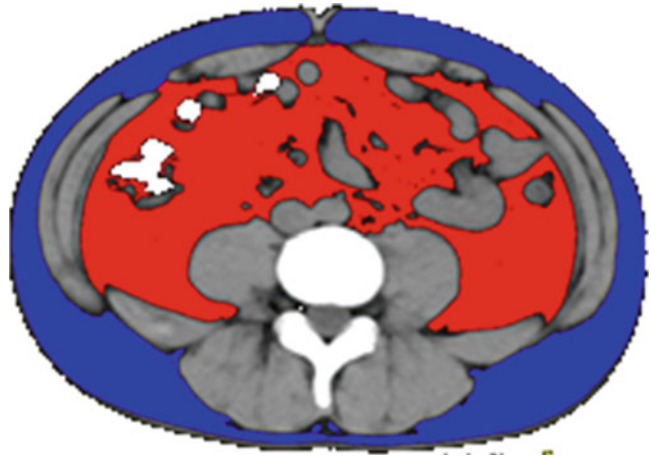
Relationship between ultrasound and computerized tomography indices for visceral fat measurement
